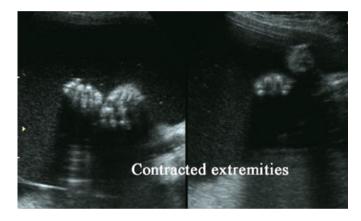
Ultrasound showing fixed flexion contractures of the upper limbs¹³.
